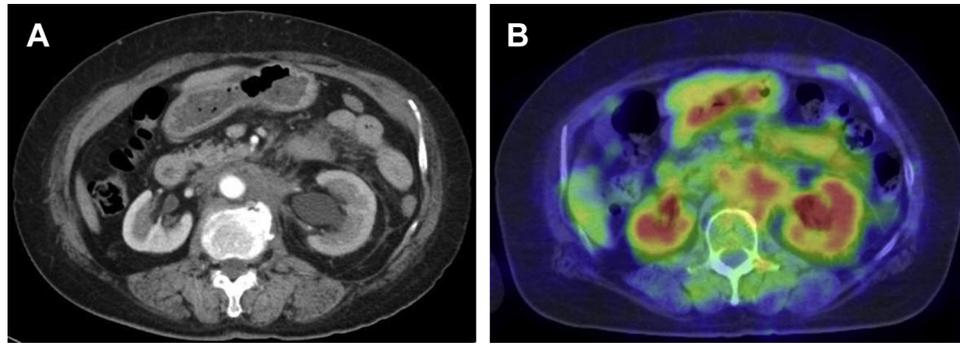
A contrast-enhanced computed tomography scan revealed a shaggy lesion around the aorta (A). The lesion had high integration of fluorodeoxyglucose (B).
